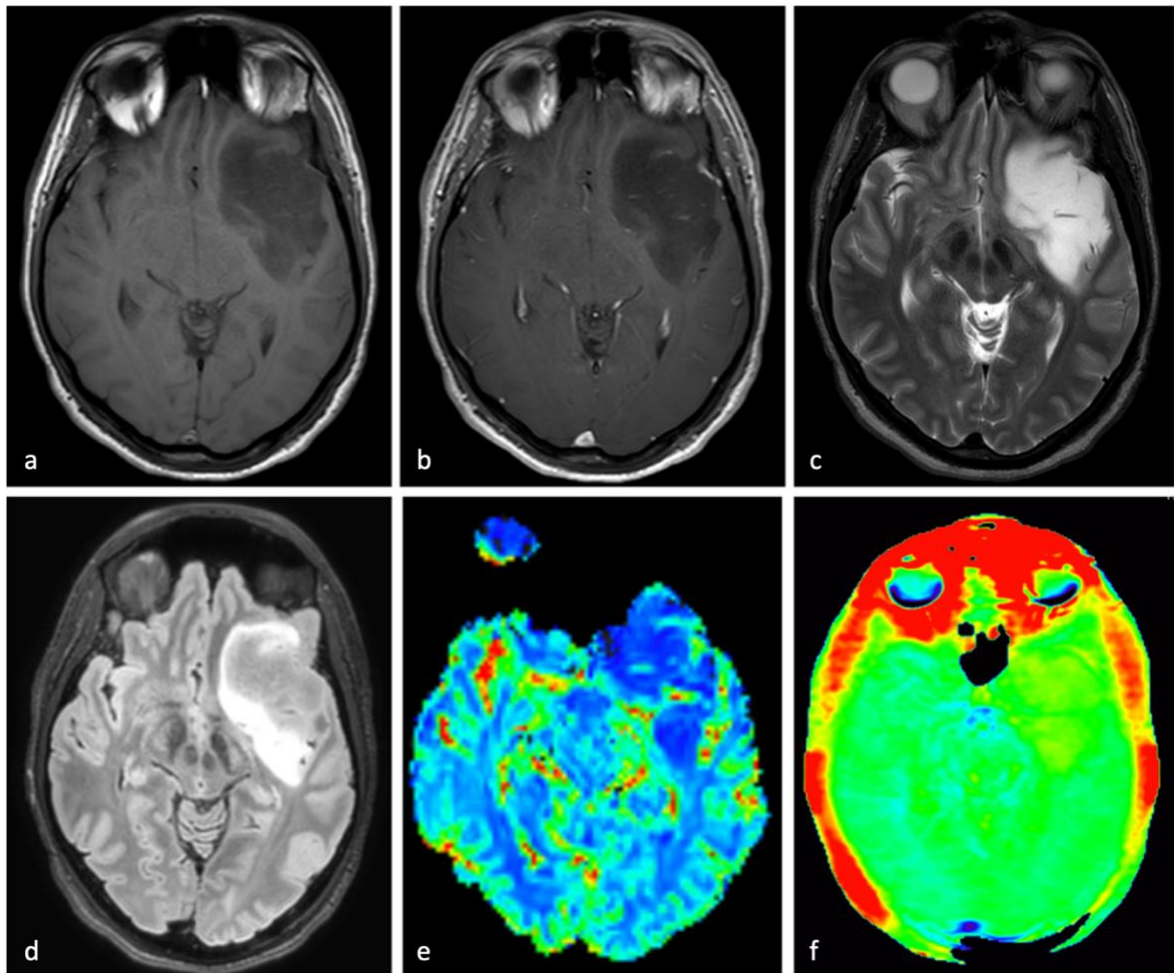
MR images of patient 3, with an astrocytoma IDH-mutated (WHO grade 3). a. T1-w image. b. Gd-T1w image. c. T2-w image. d. T2-FLAIR image. e. DSC perfusion study. f. APT-w image.
